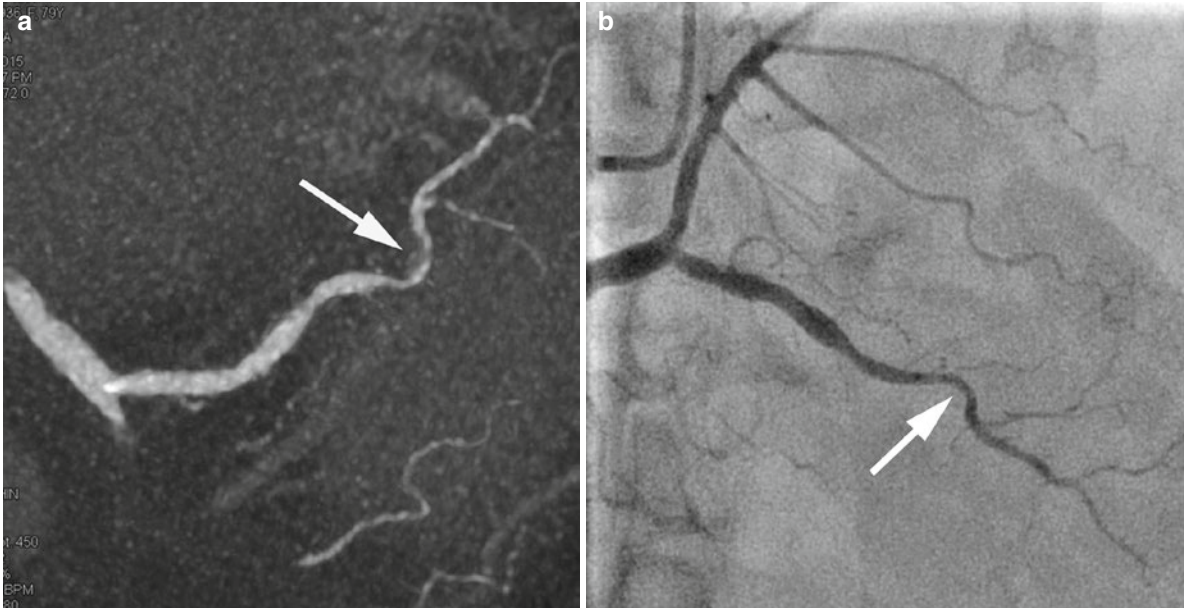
Spontaneous intramural hematoma of the left anterior descending coronary artery. (a) and (b), Coronary CTA displays wall thickening of the left anterior descending coronary artery, which is more diffuse than typically seen in coronary atherosclerosis (arrows).
